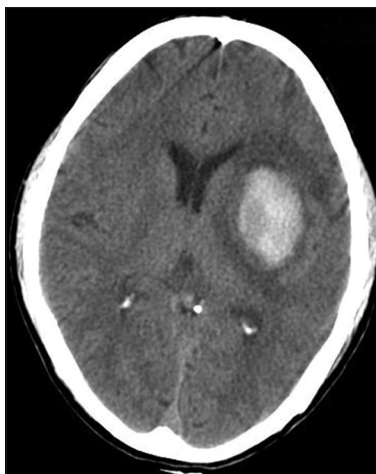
Non-contrast CT scan of the brain showing left gangliocapsular hemorrhage
